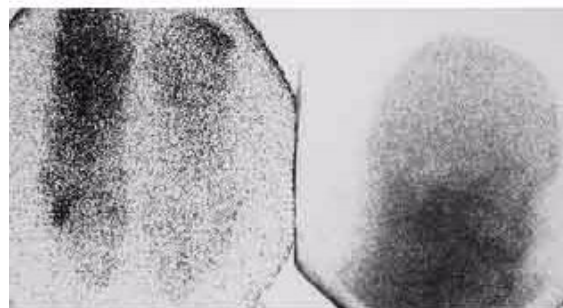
^{123}I -IAZA scintigraphic images showing focal and diffuse uptake in the feet (left panel), and absence of radioactivity (normal) in the head (right panel), of a diabetic patient.
